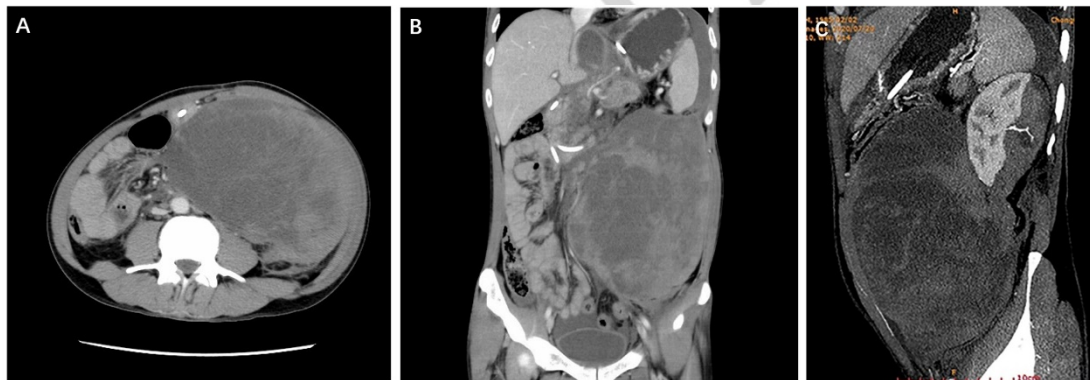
CT scan showed a massive subcapsular hematoma of the left kidney that filled the left abdominal cavity (A, B). There was extravasation of contrast at the inferior pole of the left kidney(C).
